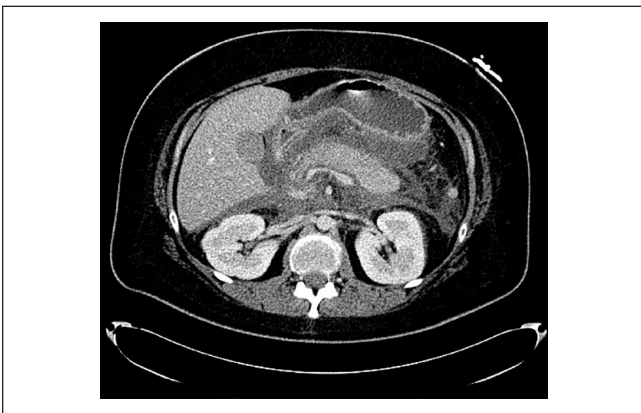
Computed tomography of the abdomen and pelvis axial view showing hypodense pancreas with peripancreatic fluid collection.
